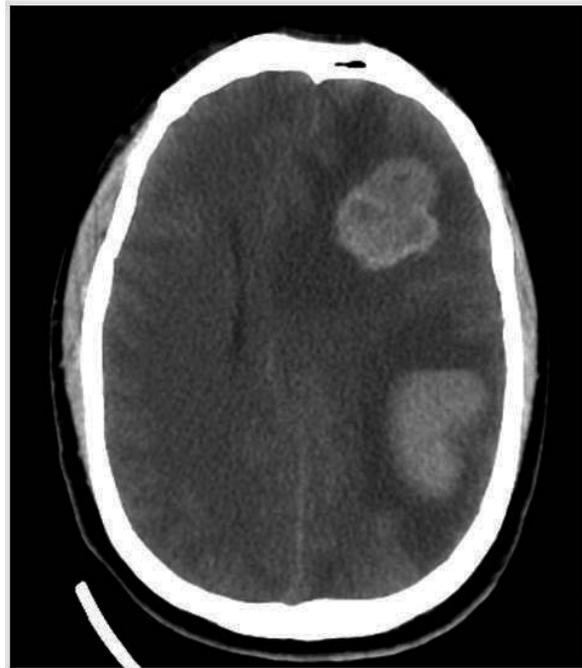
CT scan from a patient with remote history of melanoma who presented with thunderclap headache.
